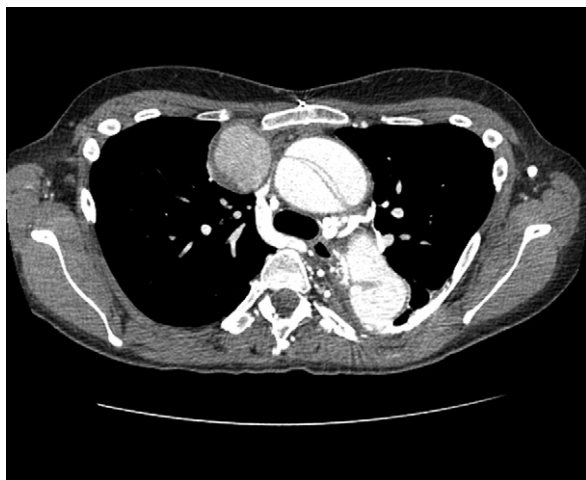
Axial CT scan demonstrating 4 cm right internal mammary artery aneurysm.
